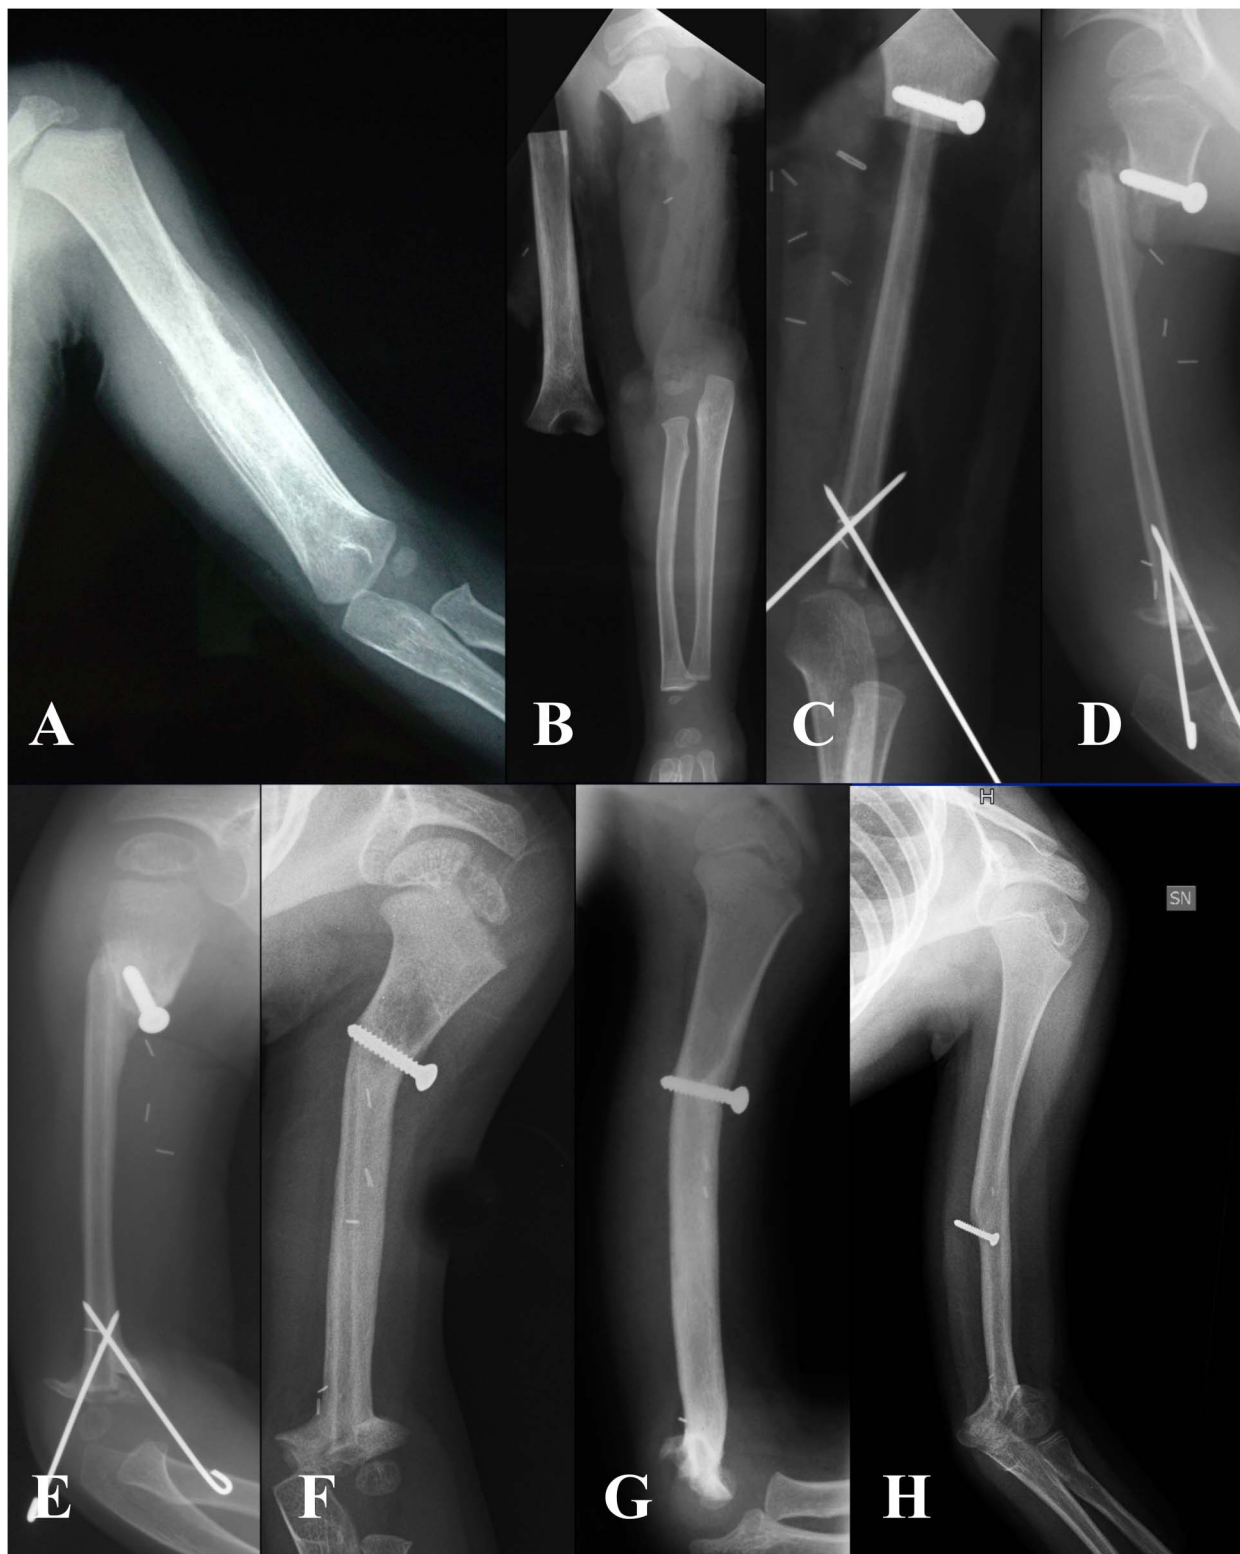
(A) This radiograph of a 2-year-old boy shows Ewing sarcoma of the humeral diaphysis. (B) The patient was treated with intercalary resection to preserve the distal epiphysis and (C) reconstruction with VFG and fixation with a proximal screw and distal K-wires. These radiographs show that (D) a VFG fracture occurred 1 month after the index surgery (E) that was managed nonoperatively and (F) healed spontaneously. (G) This radiograph shows progressive hypertrophy of the fibula. (H) The patient had loosening of the proximal screw that was removed because of radial nerve impingement 112 months after the primary surgery.
